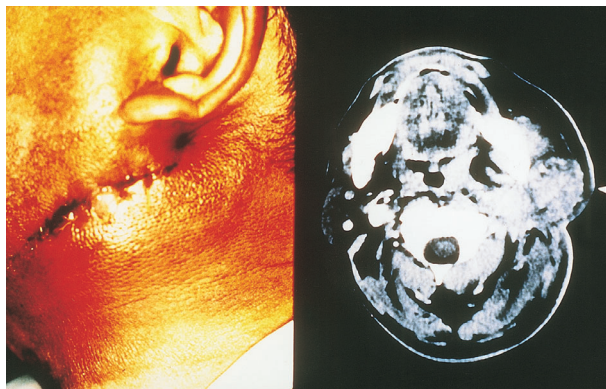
A tumor formation was seen from the left infraauricular region to the upper neck with red overlying skin(left side). Open biopsy was already done in another hospital before admission. The tumor was elastic and hard, and had poor mobility. Several swollen lymph nodes were palpable around the tumor on the left side of the neck. CT scan indicates this tumor under the skin around left parotid region(right side).
